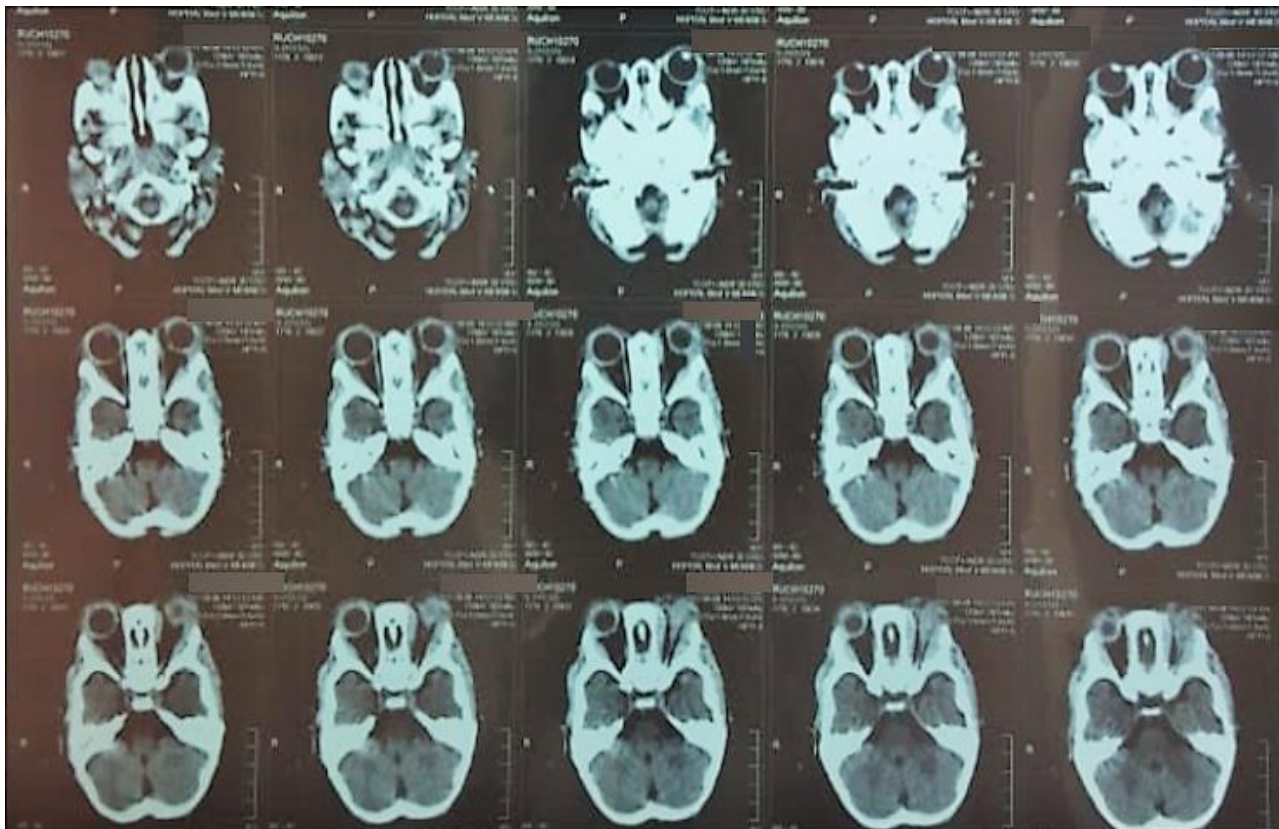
Orbital-cerebral computed tomography showing infiltration of the extra- and intra-conical space
